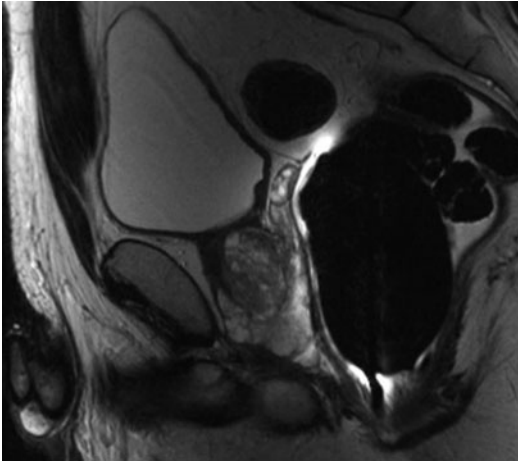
The corresponding sagittal MRI view. In this case, the anatomy of the bladder neck appears simple: no median lobe, no TURP defect, no other hypertrophied lobes
